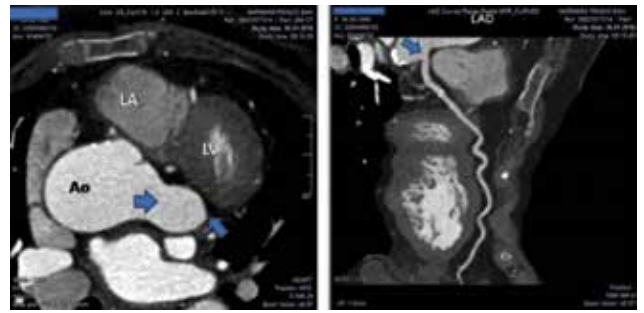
Computed tomography angiography. Arrows in the left demonstrating saccular dilatation at the level of the left sinus of valsalva while the arrow in the right showing left main coronary artery originating from the anterior wall of the aneurysm (Ao, ascending aorta, LA: left atrium, LV: left ventricle).
